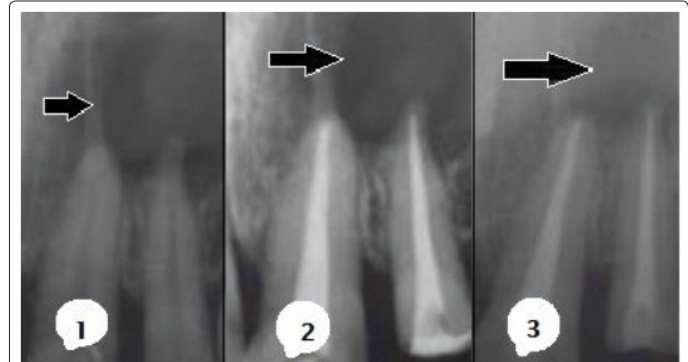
Showing periapical lesions
